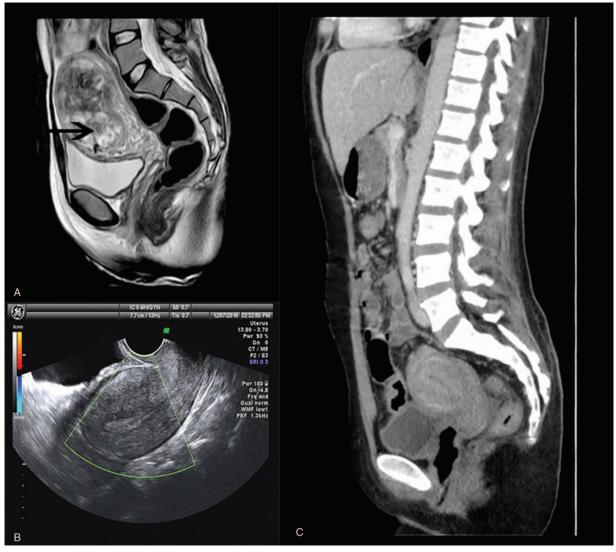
Comparison of uterine lesions. (A) Pelvic magnetic resonance imaging before chemotherapy. (B) Ultrasonography of the uterus after 3 cycles of chemotherapy. (C) Pelvic computed tomography after 3 cycles of chemotherapy.
